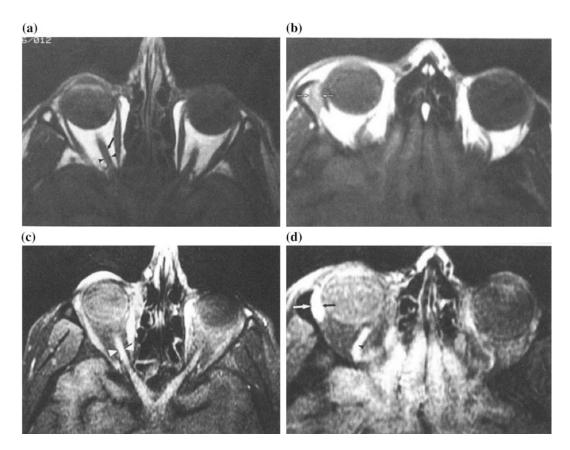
The effects of fat suppression in imaging of normal orbital anatomy demonstrated by axial T1 weighted MRI (a, b) and axial T1-weighted MRI with fat suppression (c, d). a Hyperintense fat around normal structures produces an artifact (*arrow*) that causes the optic nerve to appear enlarged (*arrowheads*). b Hyperintense fat obscures visualization of the lacrimal gland (*between arrows*). c Fat suppression better reveals the optic nerve (*arrowheads*) against low-intensity CSF. d Fat
